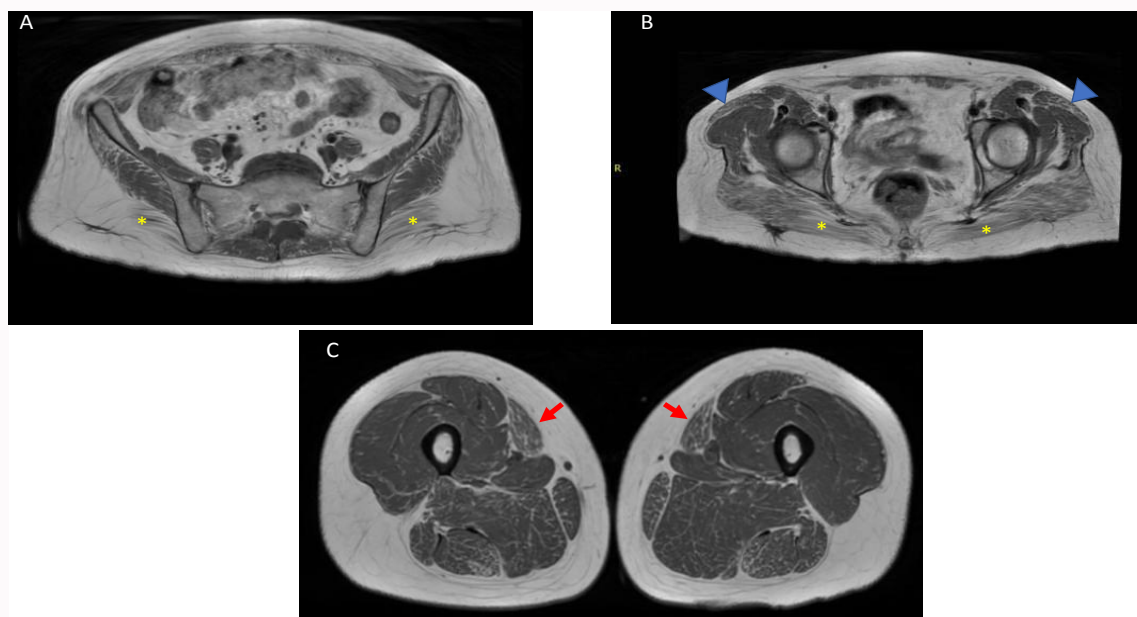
Muscle MRI. T1W images at pelvic girdle (A and B) and thighs (C). The gluteus maximus muscles (asterisks) show severe fatty infiltration and tensors fasciae latae (arrowhead) and sartorius (arrows) show moderate involvement.
